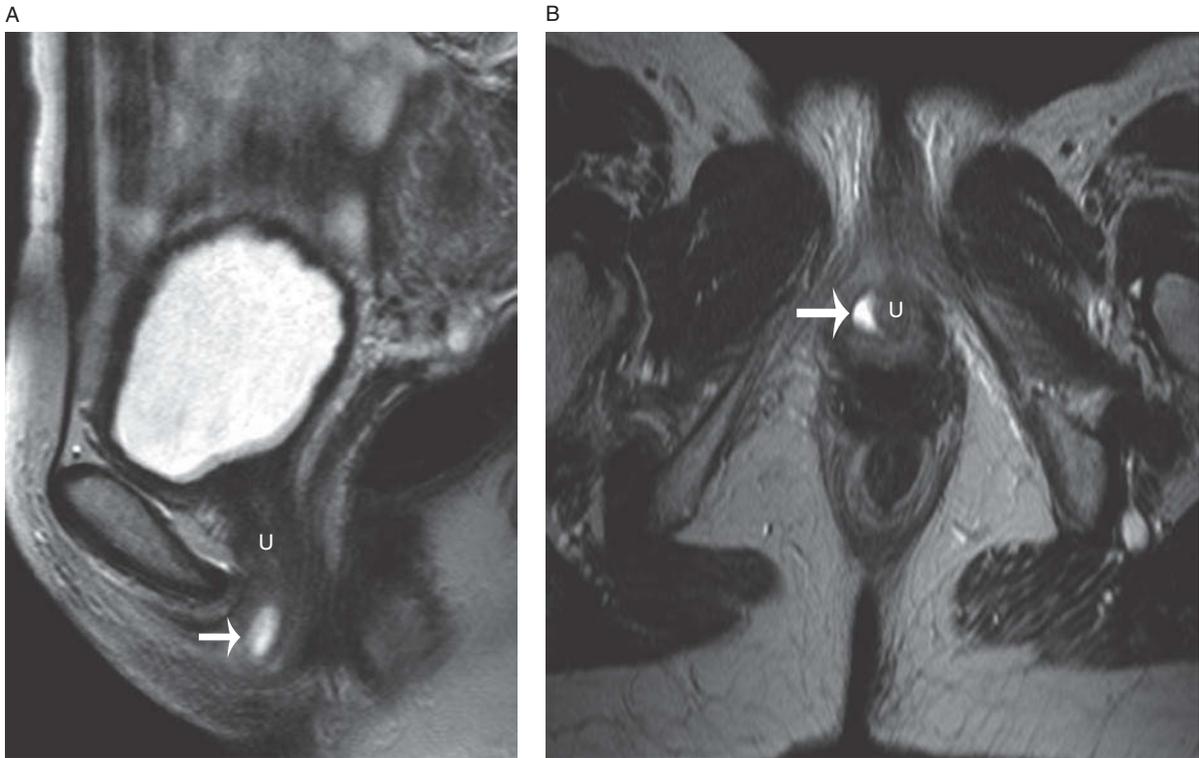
Skene's gland cyst in a 47-year-old female. Sagittal T2-weighted image (A) reveals a cyst (arrow) located distal to the urethra (U). Axial T2-weighted image (B) further reveals that the cyst (arrow) is lateral to the distal urethra (U).
